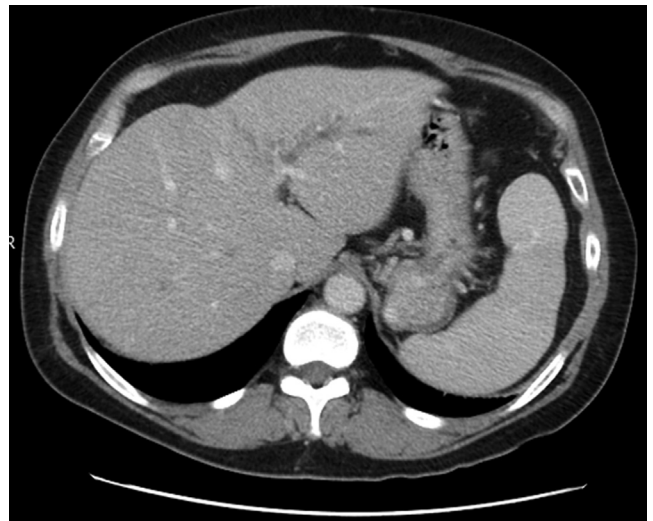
Axial section of abdominal CT scan showing a mass in the tail of the pancreas.
